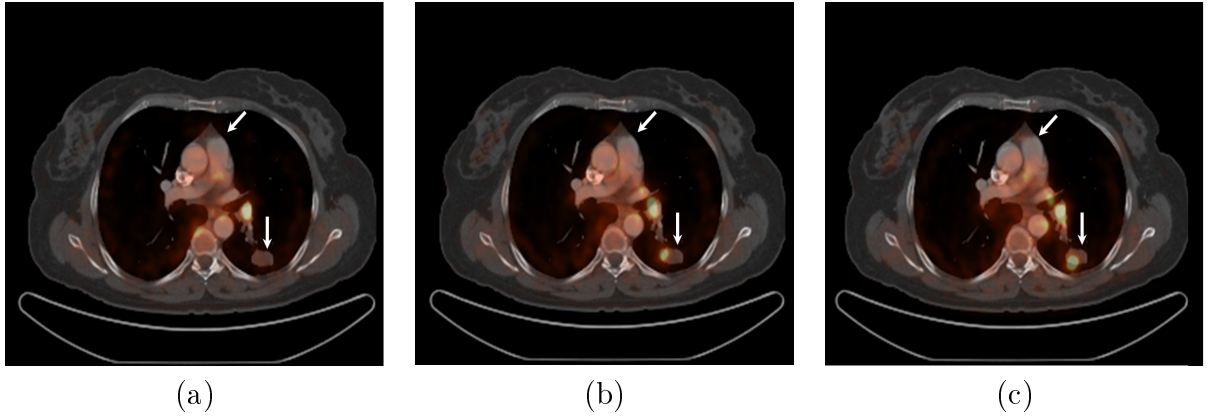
Fused diagnostic CT and PET images (Patient 6). (a) without registration (b) with classic fluid registration (c) with our proposed registration technique. The white arrows point towards the tumour. The proposed registration has been unsuccessful in complete alignment of the tumour.
